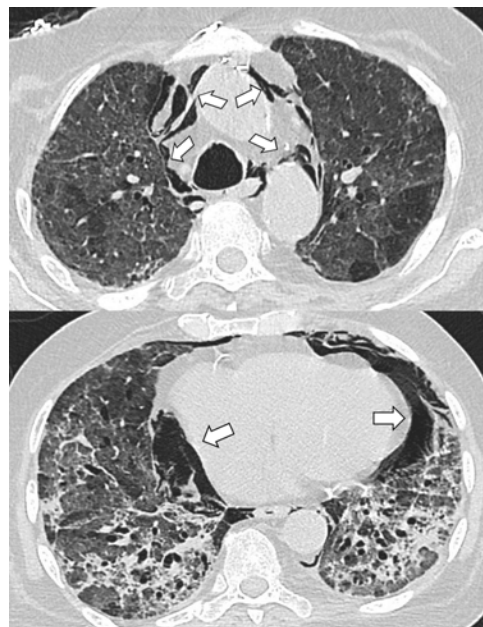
CT scan of the chest showing interval development of pneumomediastinum extending from the thoracic inlet to the diaphragm (white arrows).
